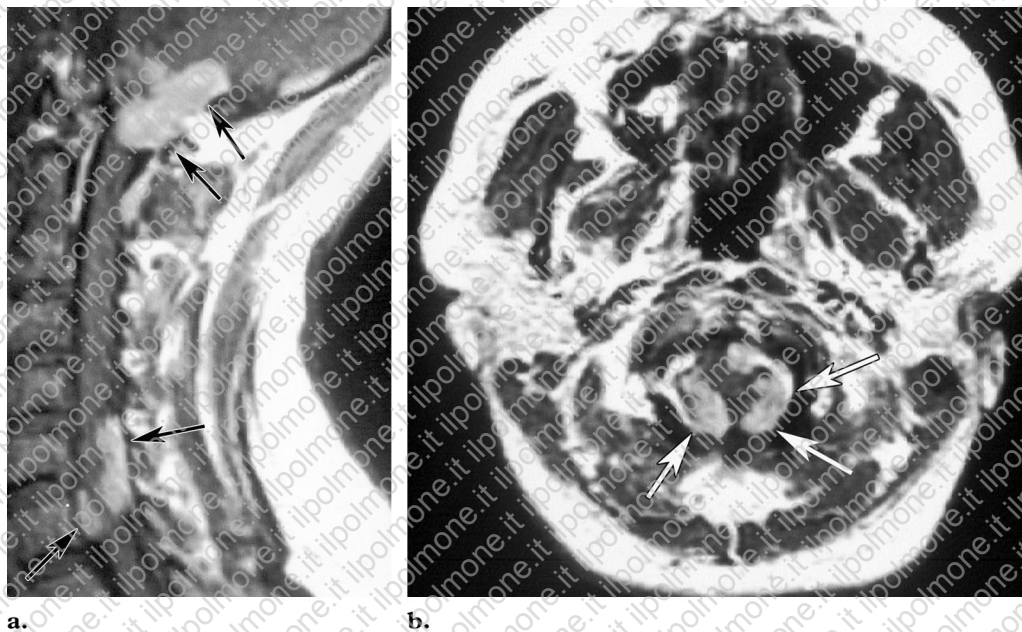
Leptomenigeal involvement in a 23-year-old woman. Sagittal (a) and axial (b) contrast-enhanced T1-weighted MR images show diffusely enhancing leptomenigeal lesions (arrows) surrounding the upper cervical spinal cord.
